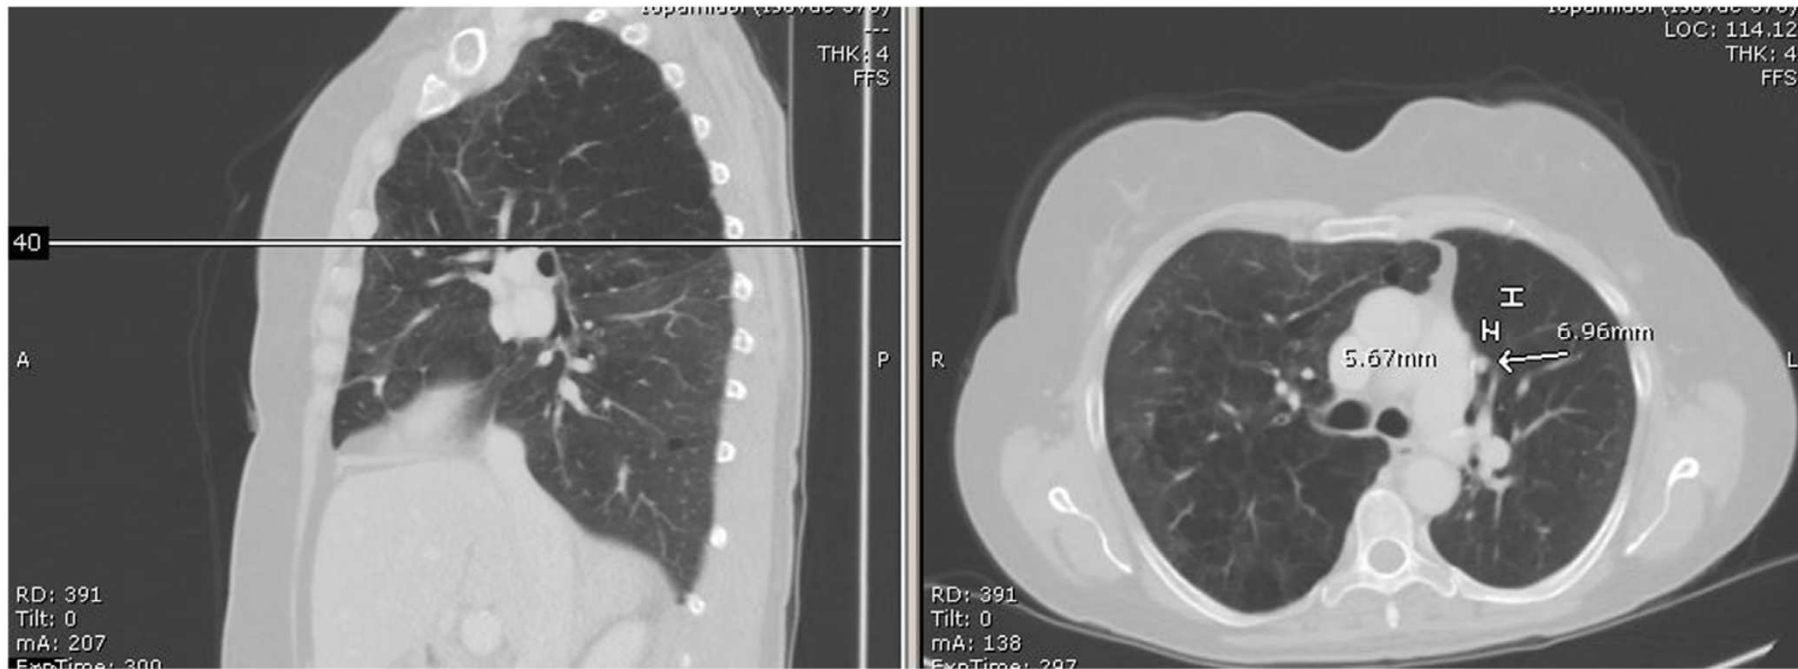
Gallium PET/CT scan (A, B); CT scan with contrast (C)
